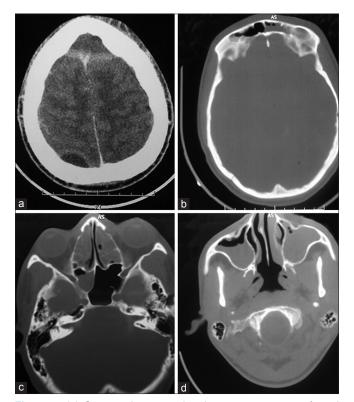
(a) Computed tomography showing post-sinusitic frontal and right occipital extradural abscesses. (b) Abscess collection within the frontal air sinus. (c) Abscess within the ethmoidal sinuses. (d) Abscesses within the maxillary sinuses
